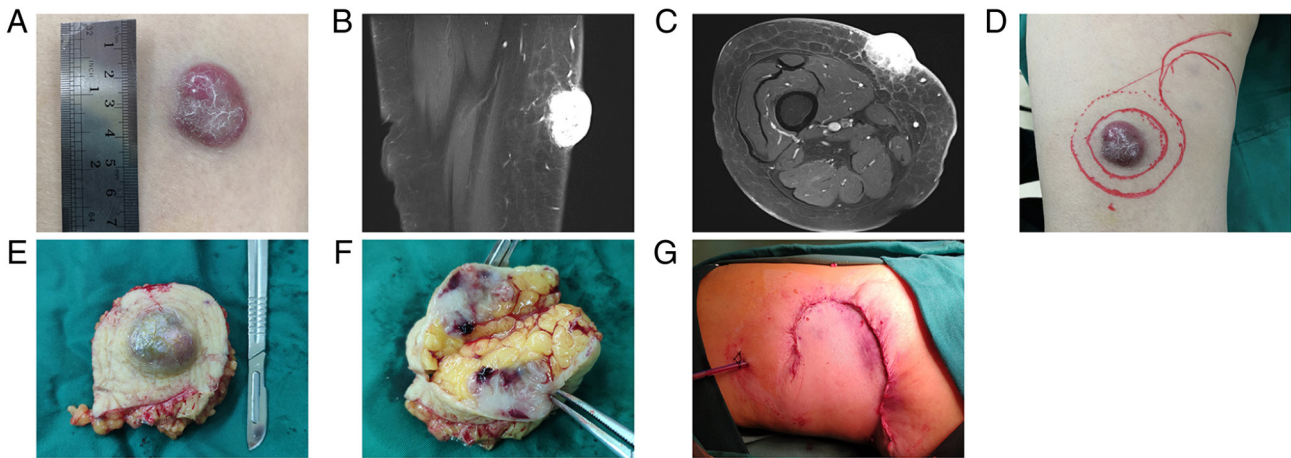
Intraoperative presentation. (A) Image of the 3x3 cm cutaneous tumor on the right thigh. (B) Sagittal MRI. (C) Transverse MRI. (D) A 2-cm resection margin. (E) Complete resection of the tumor. (F) Resection margin reached the subcutaneous adipose layer. (G) Tension-relieving suture.
